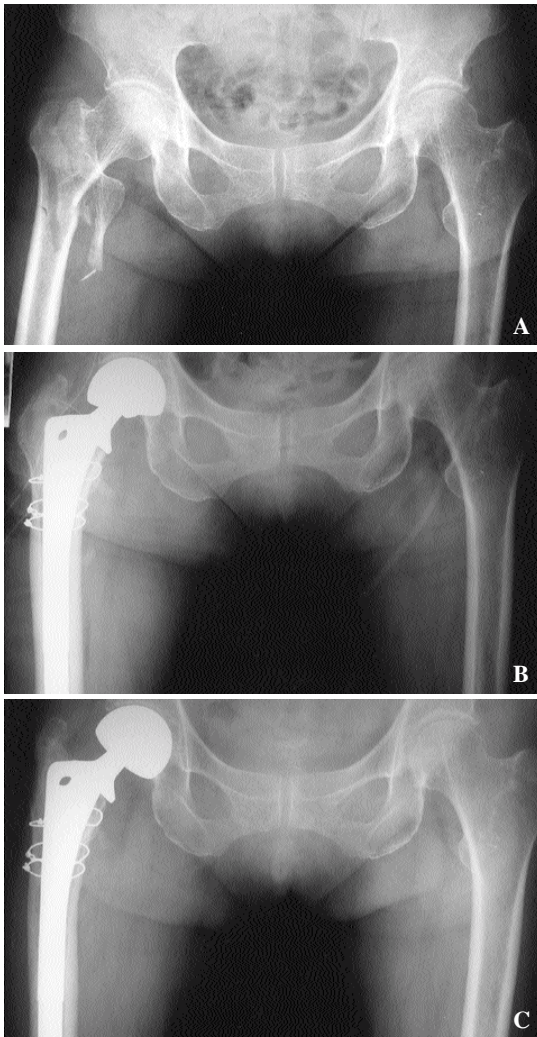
Serial radiograph of 78 year old woman treated by a noncemented bipolar hemiarthroplasty. A. Evans unstable intertrochanteric fracture. Preoperative radiograph. B. Immediate postoperative radiograph. C. Postoperative 2 years radiograph showed satisfactory result.
